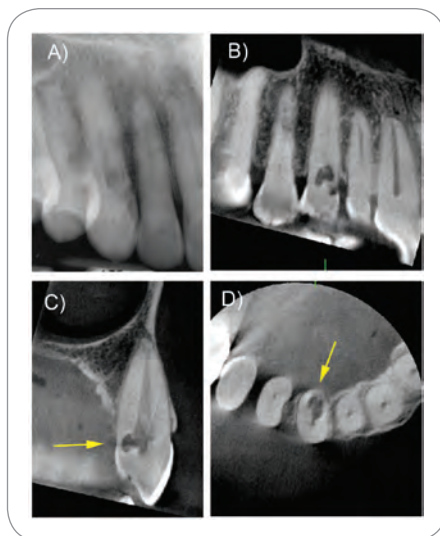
Panoramic radiography (A), sagittal (B), cross-sectional (C), and axial (D) CBCT sections of tooth No. 27 demonstrate the presence and severity of external (red arrow) and internal root resorption. Yellow arrow points to the extension of internal resorption to the lingual tooth surface.
